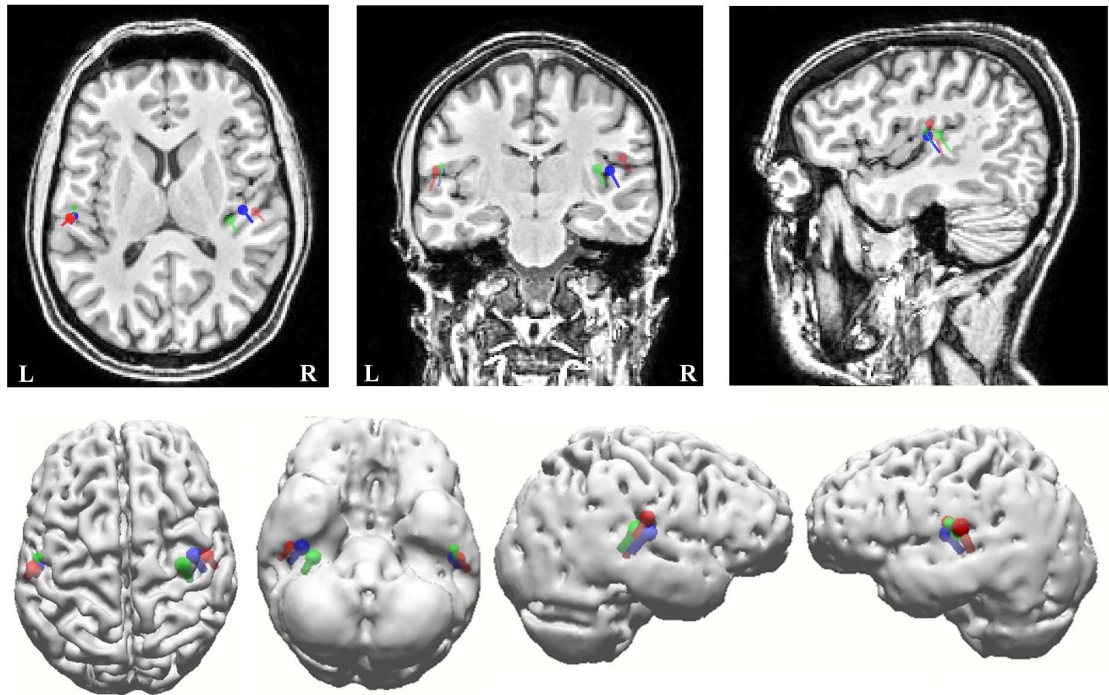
EMEG source reconstructions for auditory stimulation with sinusoidal tones with 250 (red), 1000 (blue) and 4000 (green) Hz are shown on the MRI (upper figures) and on a volume rendering of the brain (lower figures)
